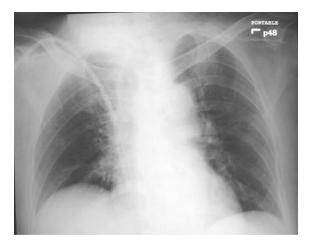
Chest roentgenogram on the first day of influenzalike illness. Lung parenchyma was clear
